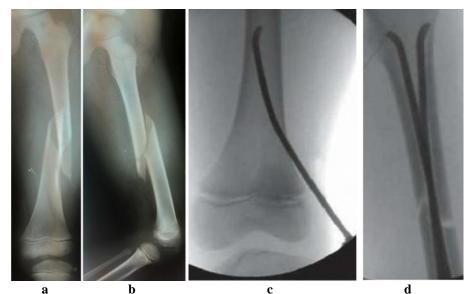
a & b. X-ray of spiral Fracture shaft of femur AP and Lateral view; c. Advance the nail through the drilled entry hole; d. Both nails are advanced after the reduction that nail.
